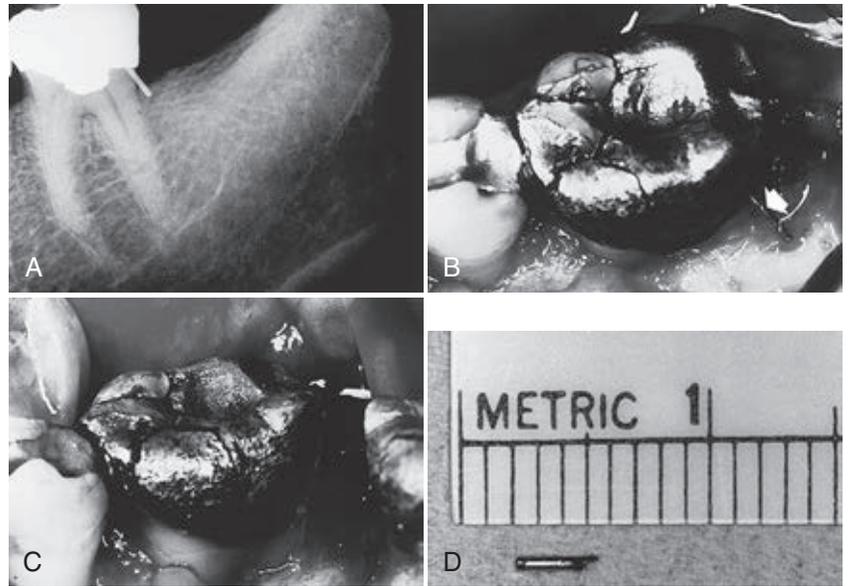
External perforation of a pin. A, Radiograph showing the external perforation of a pin. B, Surgical access to extruding pin (arrow). C, Pin cut flush with the tooth structure and crown-lengthening procedure performed. D, Length of pin removed.
